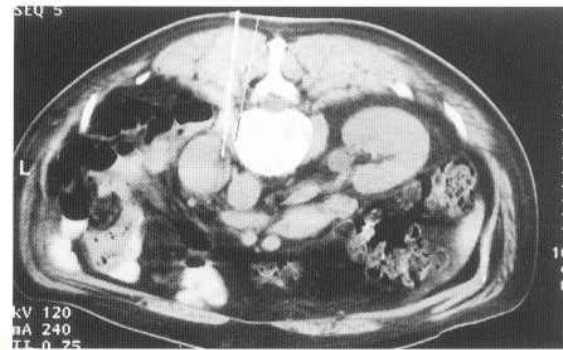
CT-guided biopsy. An 18 gauge cutting needle has been positioned in a solid mass in the right renal bed under CT guidance. The core of tissue obtained confirmed recurrent renal cell carcinoma.
